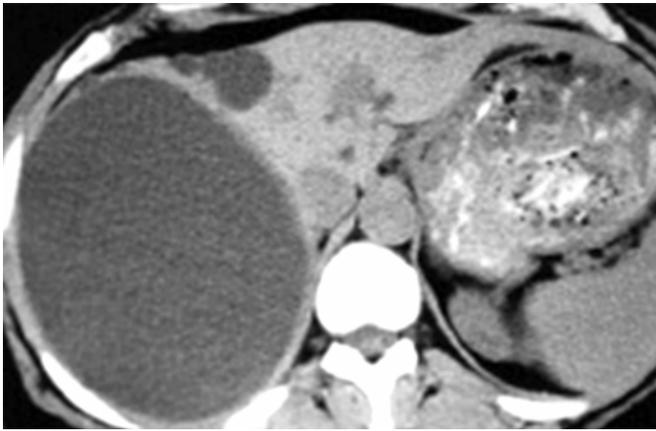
Computed tomography (CT) scan appearance of a large hepatic cyst
